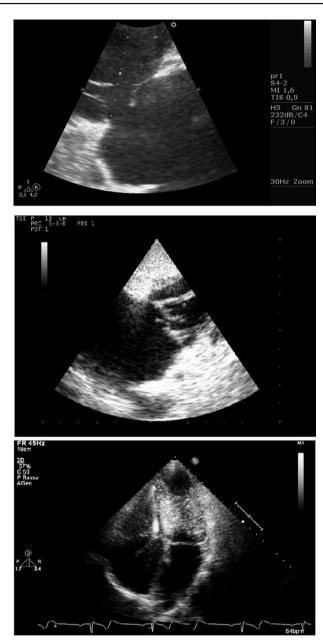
Top: Echocardiographic image of the tricuspid flail leaflet in case patient 1. Middle: Echocardiographic image of the tricuspid flail leaflet in case patient 2. Bottom: Echocardiographic image of the tricuspid flail leaflet in case patient 3.
